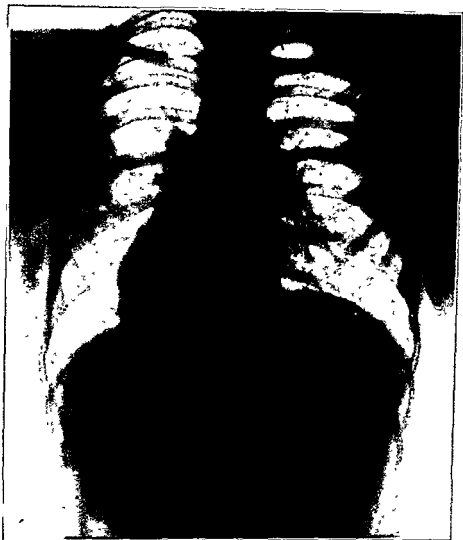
Figs 63 to 68 inclusive demonstrate the pathogenesis of chronic productive tuberculosis. Fig 63 is an x-ray of a boy 11 years of age examined because of contact with an open case of tuberculosis. Physical examination revealed no abnormal findings. The boy had no symptoms. In the apex of the left upper lobe a minimal conglomeration of acinous infiltration was noted.
